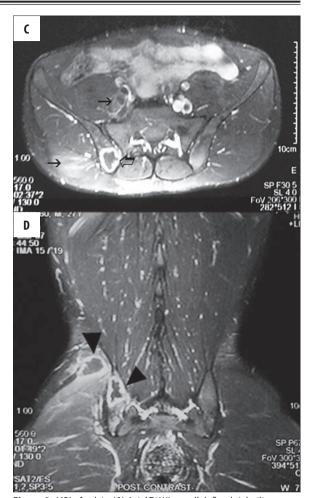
MRI of pelvis: (A) Axial T1WI: a well defined right iliac bone lesion adjacent to the sacro-iliac joint showing low signal intensity (open arrow); two further slightly hyper intense soft tissue lesions; one is abutting the right iliacus and psoas muscles, another is extra-pelvic in the right gluteus maximus and medius muscles (arrows). (B) Axial T2WI: high signal intensity of the bony lesion (open arrow) as well as the intra- and extra-pelvic soft tissue lesions (arrows). (C) Axial fat suppressed T1WI after IV Gadoliniumbased contrast: uniform marginal enhancement of the iliac lesion representing bone abscess (open arrow); the intra-pelvic lesion shows enhancement with small underlying abcesses (arrow); the right gluteus muscles are also enhancing (arrow). (D) Coronal fat suppressed T1WI after IV Gadolinium-based contrast: uniform marginal enhancement of the iliac lesion representing bone abscess (arrow head); the right gluteus muscles are also enhancing
